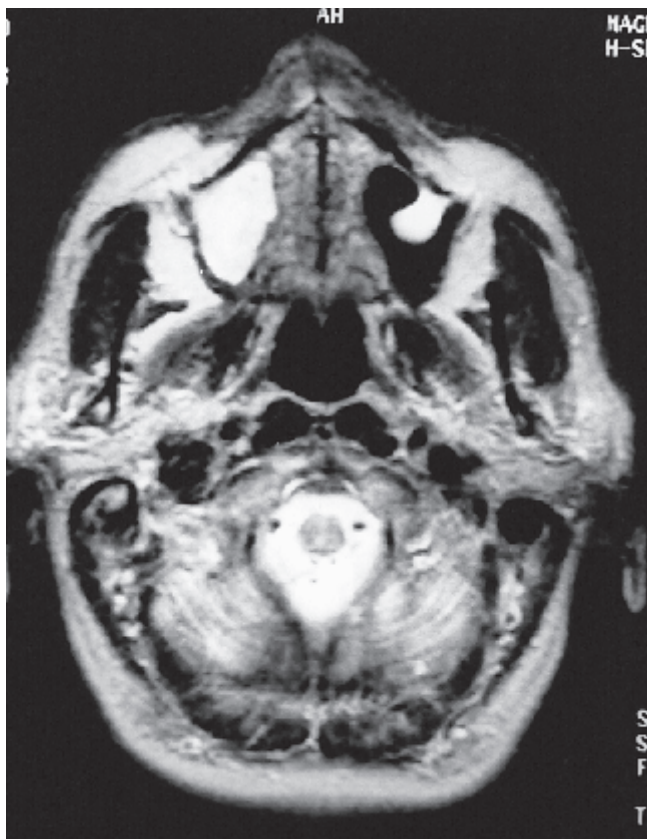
Axial MRI scan demonstrating opacification of the paranasal sinus.
